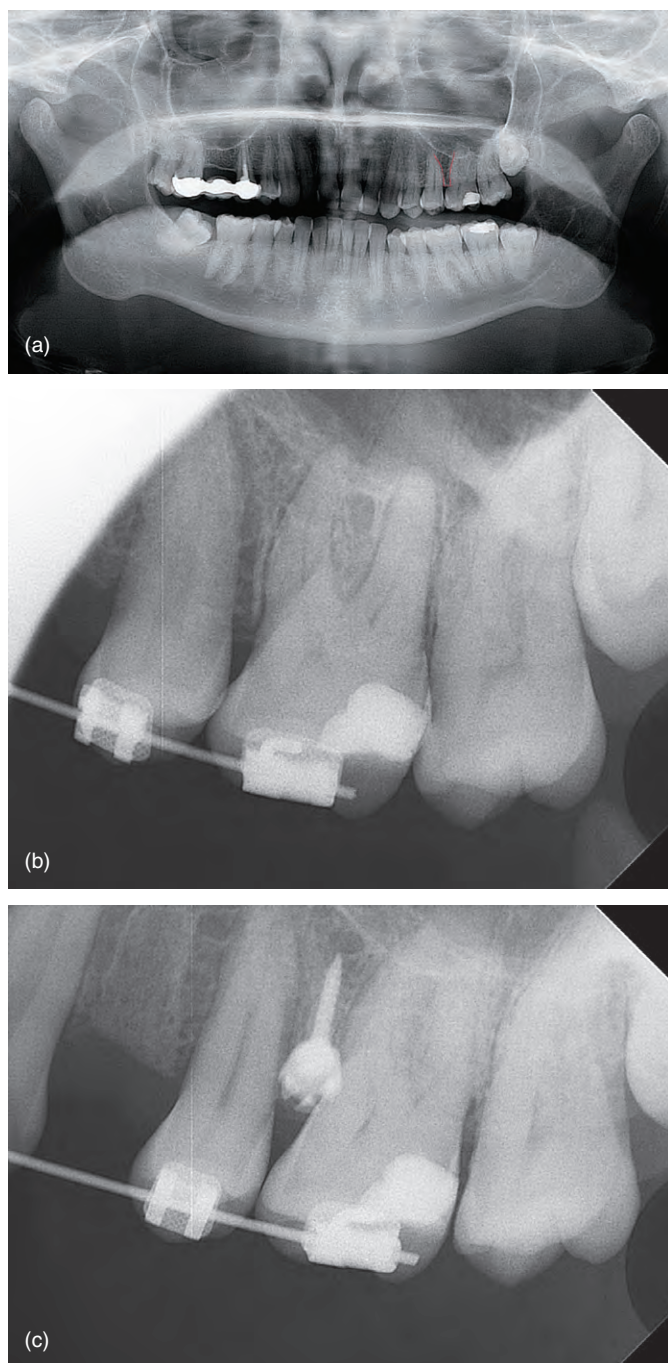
(a) Panoramic and (b) intra-oral pre-treatment radiographs of the dentition as used to visualise the interproximal area between the left maxillary second premolar and first molar teeth. (c) The intra-oral radiograph is repeated to confirm the position of a mini-implant in this site.
